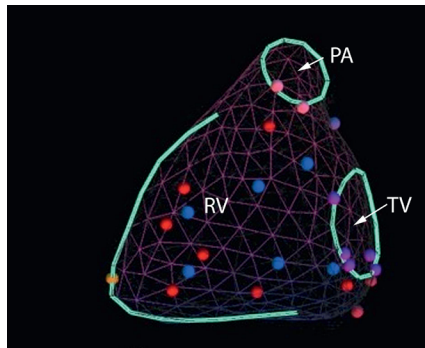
RV volume calculated using knowledge-based reconstruction. This technique is based on placing reference points on transthoracic 2DE images of different projections of the right ventricle, using a defined protocol and a tracked probe. Each of the points (red, blue, purple, pink, and orange) represents a specific reference point. The full volume is reconstructed by uploading the information to a server which is linked to a disease specific atlas to complete the contouring and volume generation. TV, tricuspid valve; RV, right ventricle; PA, pulmonary artery.
